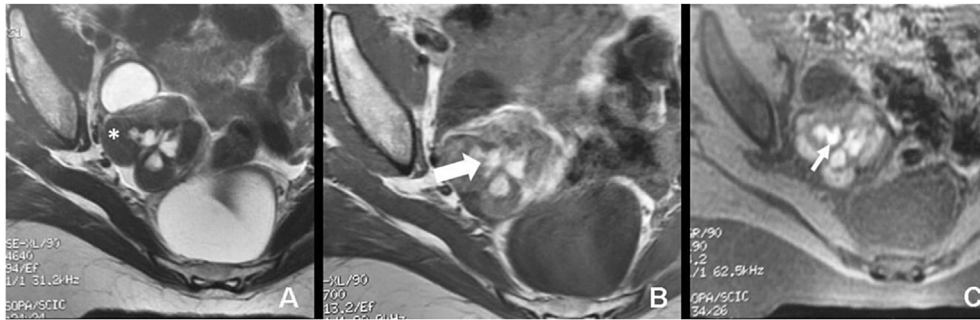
Different appearance of ileal endometriosis in (A) T2, (B) T1, and (C) T1-weighted images with (D) fat suppression. Pelvic ileum is thickened (*), with rounded images hyperintense in T2 and T1 that correspond to deep endometriosis foci (thick arrow). Axial T1-weighted image with fat suppression demonstrates improved contrast and conspicuity of the same lesions due to bloody content (thin arrow).
